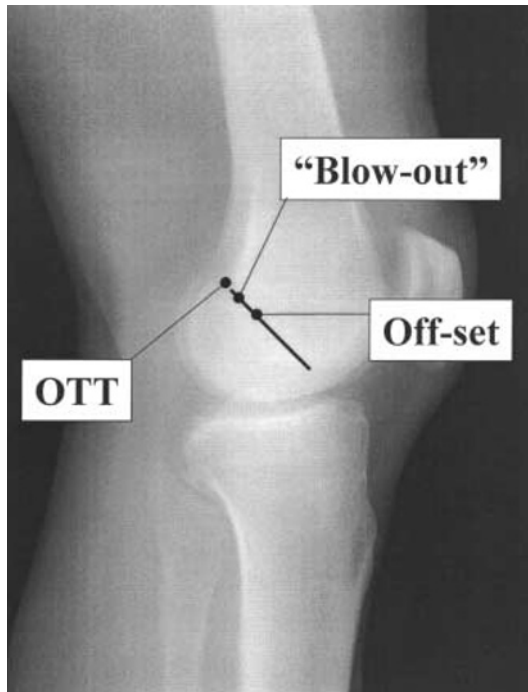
Lateral radiograph demonstrating three placements for femoral tunnels for ACL reconstruction: *OTT* over-the-top; *Blow-out* blow-out posterior cortex; *Off-set* by up to 7mm
